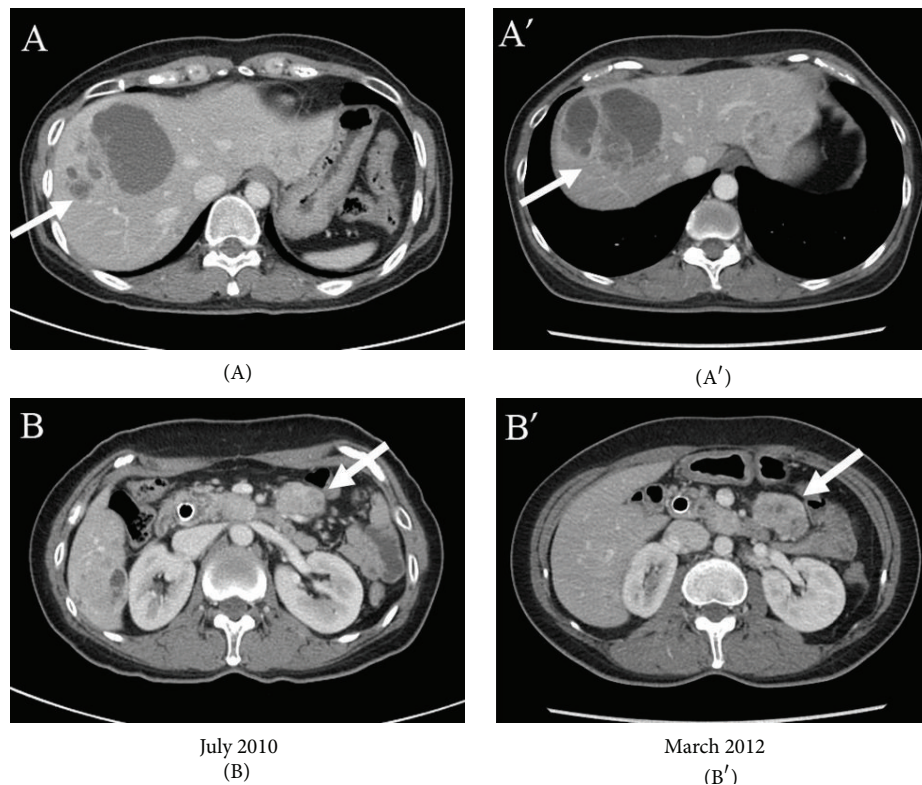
An abdominal CT scan in July 2010 revealed a necrotic metastatic lesion in the right lobe of liver and a metastatic mass in mesentery LUQ ((A) & (B)). After only aRVS treatment, a recent abdominal CT scan in March 2012 showed slight increase in size of metastatic masses over 20 months ((A') and (B')).
